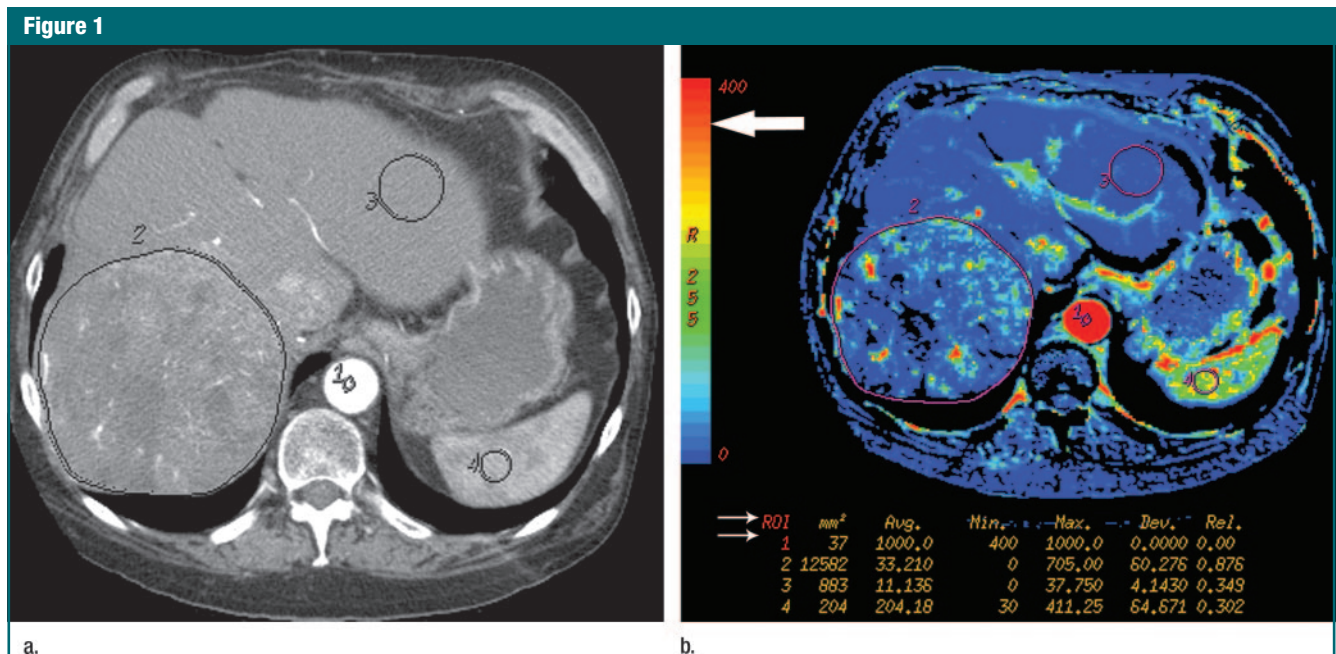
(a) Transverse contrast material–enhanced CT image and (b) functional CT perfusion color map of BF demonstrate technique of CT perfusion in a patient with HCC in right lobe of liver. Various ROIs in aorta (1), tumor (2), normal liver (3) and spleen (4) were drawn. Functional color maps for each perfusion parameter were displayed according to color scale (large arrow), and average perfusion values for each ROI (small arrows) were obtained.
